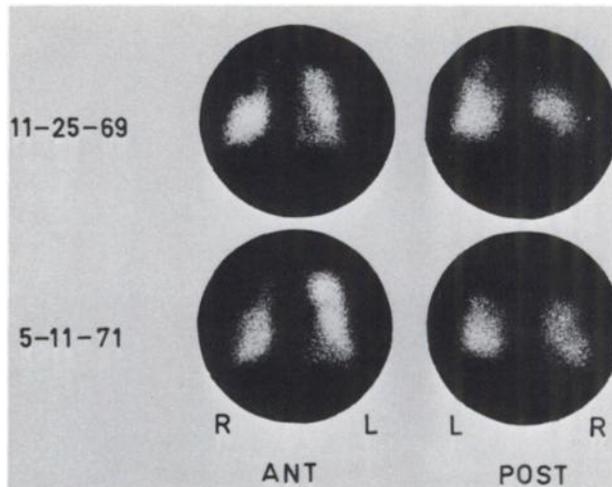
Two scintigraphic studies at 18-month interval showing no significant variation in size or location of lesions.
